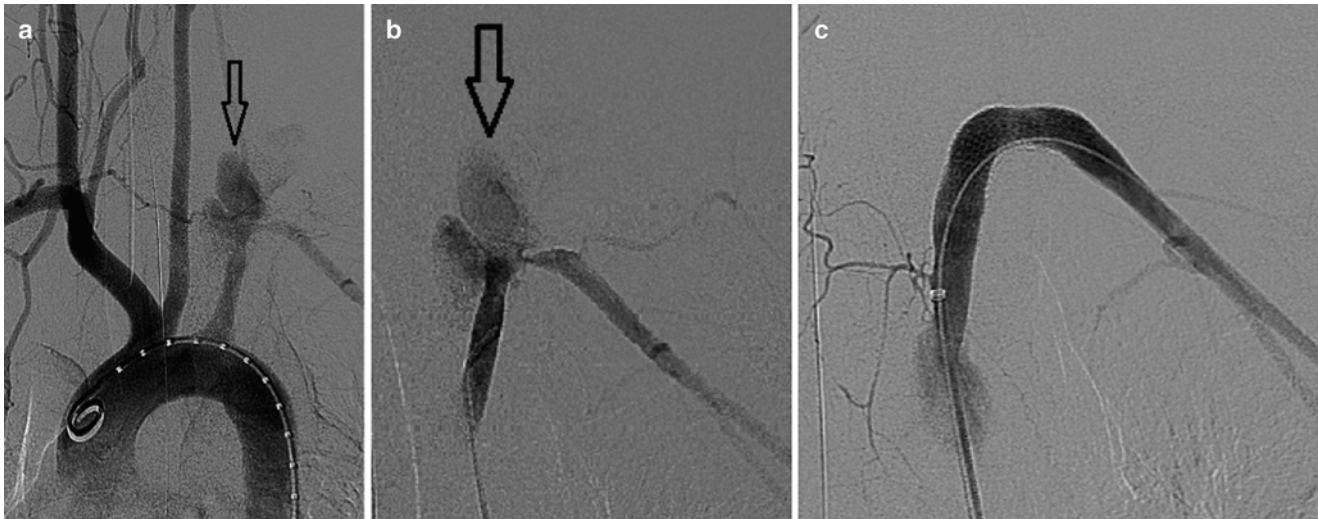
This patient presented with a large hematoma after a stab wound to the neck in Zone I. CTA demonstrated a large pseudoaneurysm of the subclavian artery (arrow), and he was taken for arteriogram (a, b). The defect was repaired with a stent graft delivered via a femoral artery cutdown (c)
